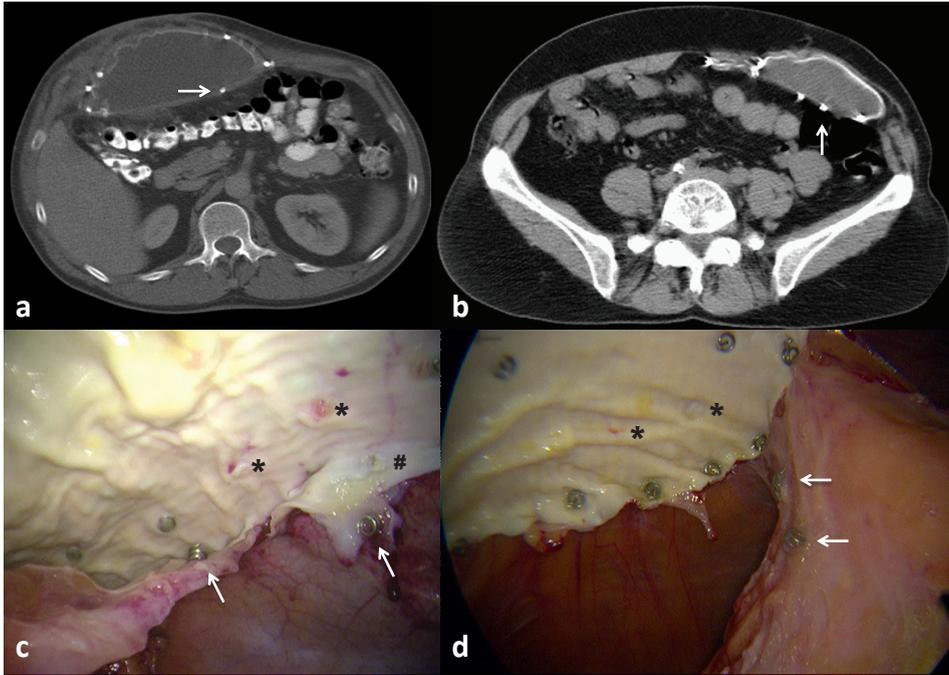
a and b Loose tacks from the inner ring as seen on a CT scan (arrows). c and d Tacks still held firmly in the thick neoperitoneum (arrows). Their imprint on the mesh was still seen at the inner ring (*) as well as the outer ring (#)
